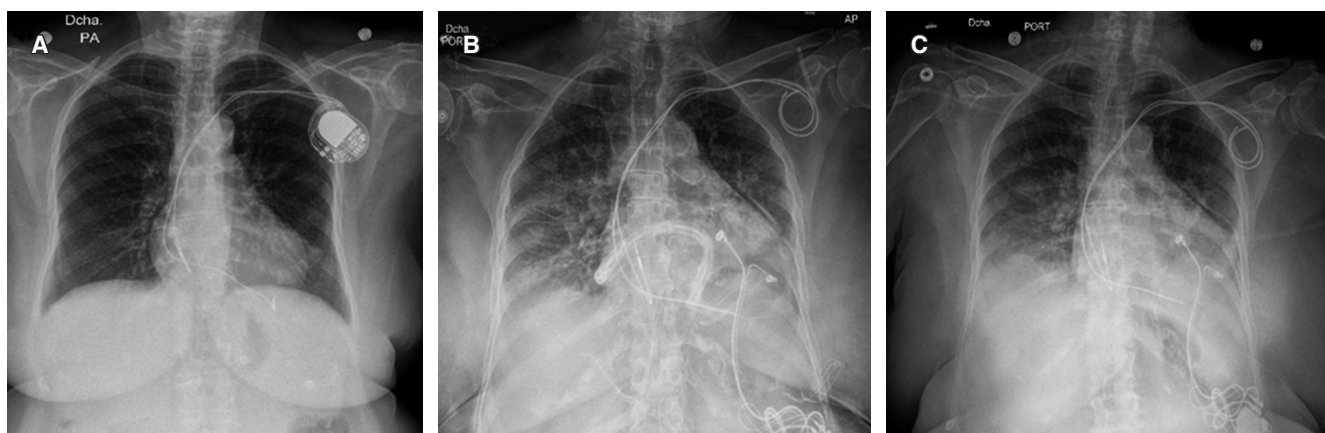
A) Anteroposterior chest X-ray upon admission to the service. A left dual-chamber pacemaker is observed, with one electrode located in the right atrium and another toward the free wall of the right ventricle with myocardial perforation and migration toward the mediastinum. B) Anteroposterior chest X-ray immediately after the pacemaker replacement procedure. Presence of mediastinal probe. Left metal electrodes without a pacemaker source, with the presence of a second functional pacemaker with epicardial leads in the left chambers. C) Anteroposterior chest X-ray at the time of hospital discharge. Leads from the previous dual-chamber pacemaker without a pacemaker source remain, with the presence of a second functional pacemaker with epicardial leads in the left chambers.
